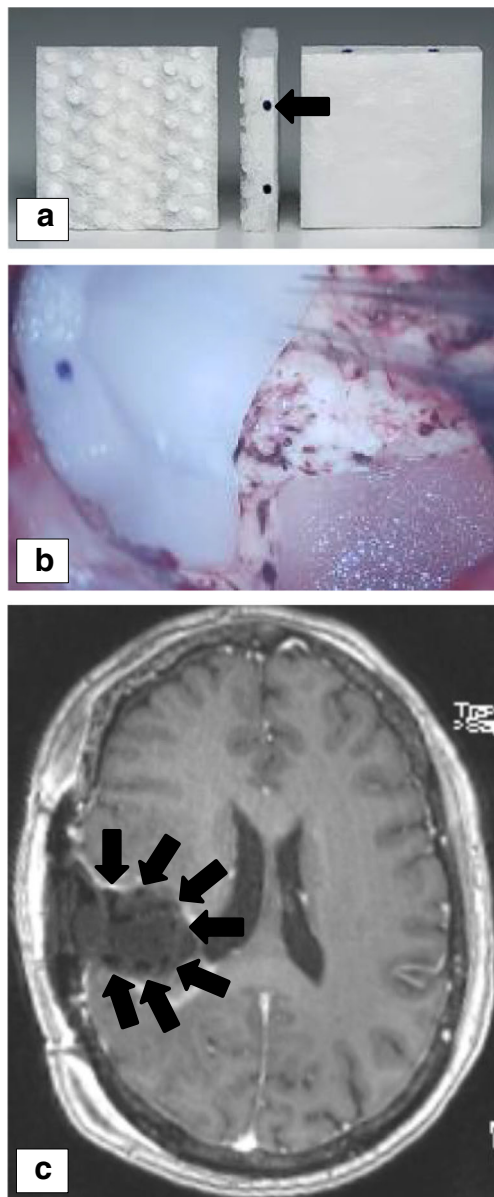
a Photo of the 20 mm × 20 mm × 4 mm GammaTile. Arrow denotes one of the cesium-131 seeds. Photo courtesy of GT Medical Technologies (www.gtmedtech.com). b Intra-operative picture of multiple GammaTiles lining a surgical cavity. Photo courtesy of Dr. Clark Chen, neurosurgeon at the University of Minnesota. c Post-operative MRI demonstrating placement of GammaTiles (arrows)
